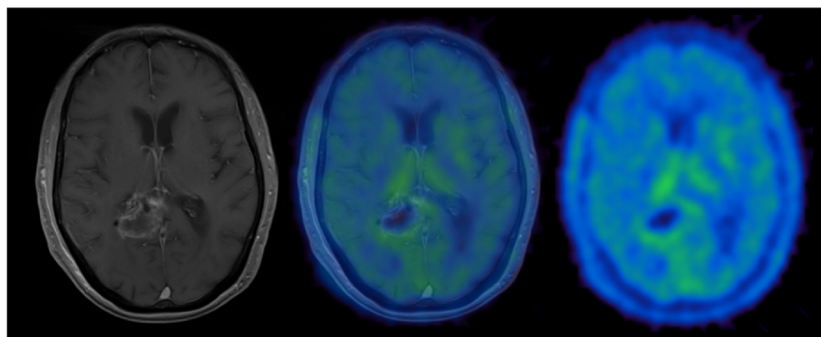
A glioblastoma patient following radiochemotherapy; while there is still contrast enhancement visible on MRI reflecting BBB disruption or possibly viable tumor cells, no relevant uptake can be observed on [^{18}F]FET-PET corresponding to complete response.
